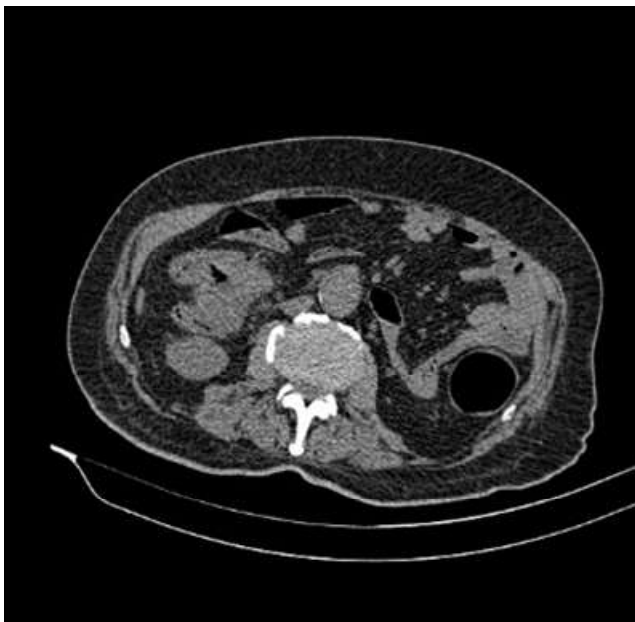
CT scan depicting colon mass in splenic flexure
